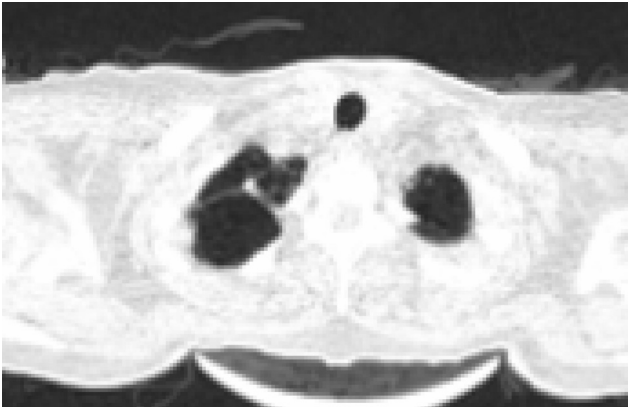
HRCT chest showing emphysematous changes in upper lobes.
